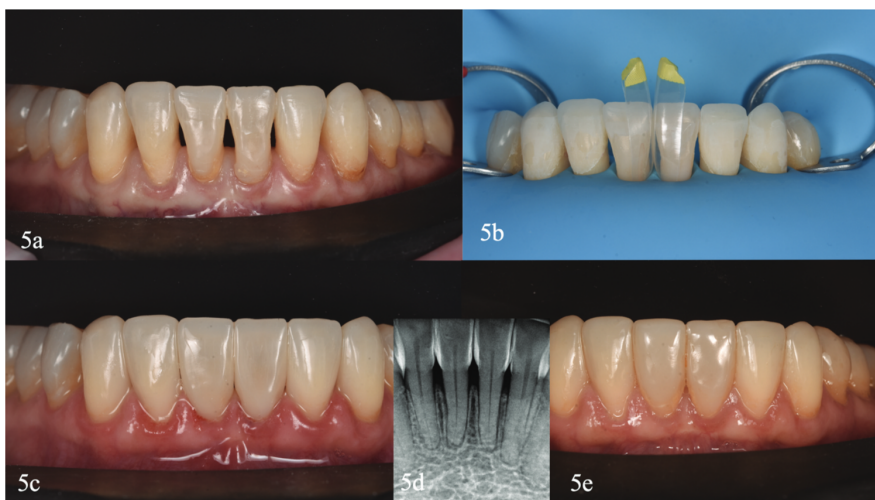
Clinical case III. (a) Initial lower intraoral front view. (b) Detail of the isolated teeth. The small yellow specific matrices for black triangles installed on the central black triangle (black triangle kit. Bioclear matrix systems. Bioclear) can be seen. (c) Immediate result just after removed the rubber dam. (d) Two weeks radiographic control (e) Two years review, highlighting the periodontal health and good polish of the restorations.
